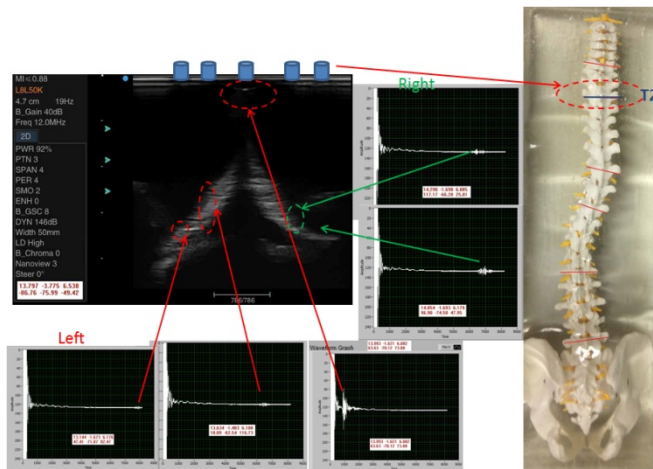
B-mode image of T2 vertebrae, and the corresponding A-mode signals measured on the same location with flexible ultrasound transducer.
